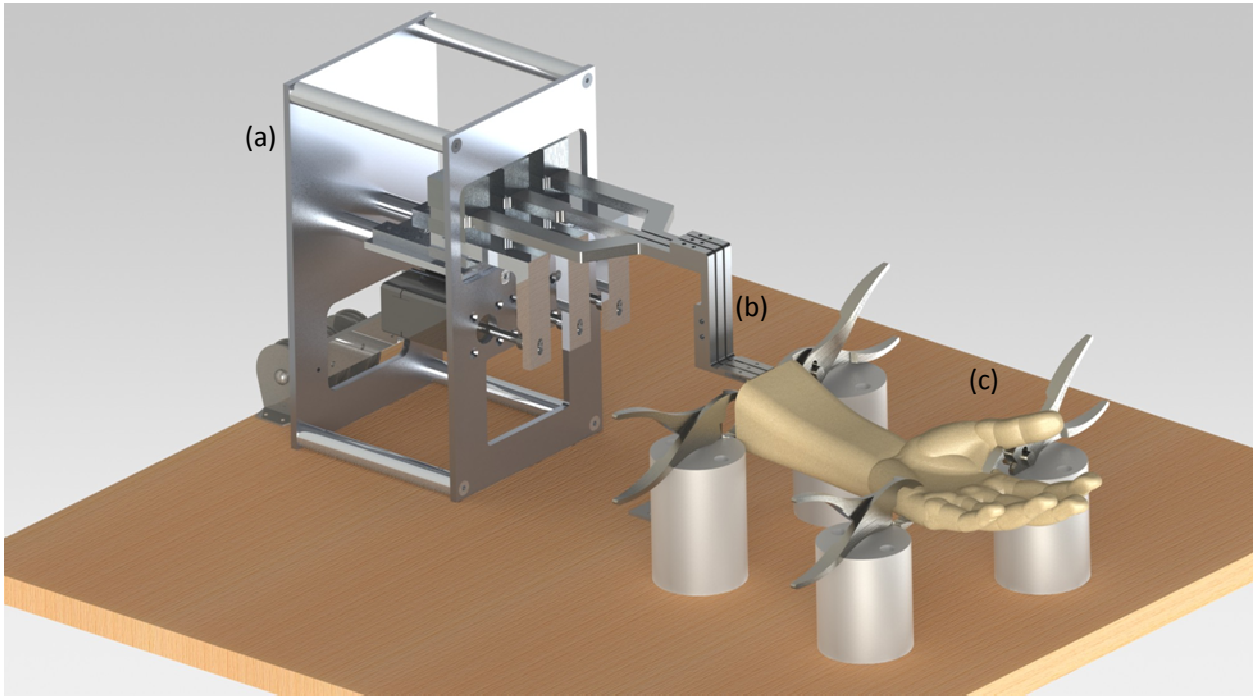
The hardware for Experiment 3 is comprised of: (a) a multi-tendon actuation system, (b) tendon couplers, and (c) a hand stabilization system. Other components not shown here include a computer, a custom electronics box containing the Galil controller and drivers, an Ultrasonix Touch ultrasound machine, and the 14 MHz linear array within the transducer holder.
